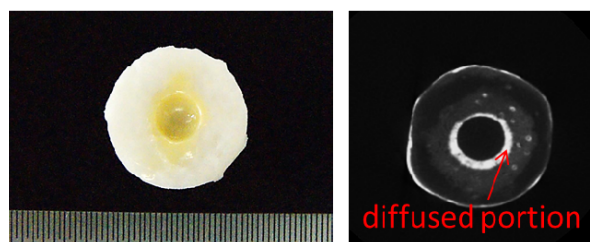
photographic image and 2-D images of complex scanned by micro focus X-ray CT.
